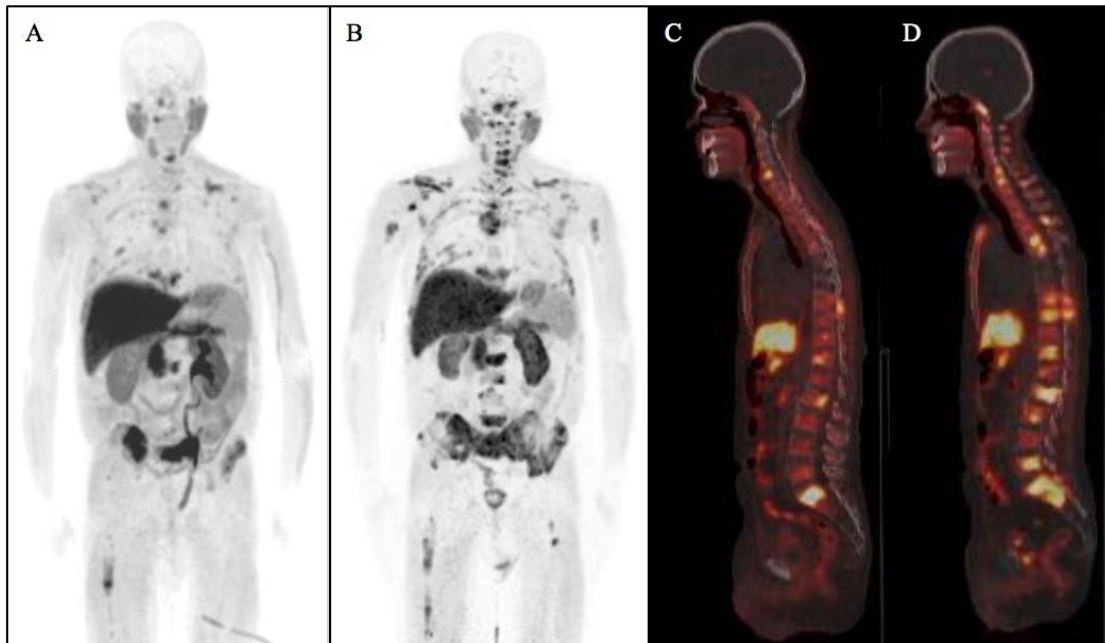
^{18}F -FCH PET/CT (A) MIP and (C) sagittal fused pre-treatment images and (B) MIP and (D) sagittal fused post-treatment images performed in a 73 years old patient affected by CRPC, GS 9. Ra223 therapy has been preceded by several lines of systemic therapy (docetaxel, cabazitaxel, abiraterone and enzalutamide). (A, C) Pre-treatment tumor burden was more than 20 bone lesions, but his hematological function needs to be supported by blood transfusion and erythropoietin therapy. Only after increasing hemoglobin level, he started and completed Ra223-therapy. (B, D) Post-treatment ^{18}F -FCH PET/CT showed disease progression with an increased number of bone metastases. However, he had an improvement in clinical symptoms (slight vs moderate pain).
